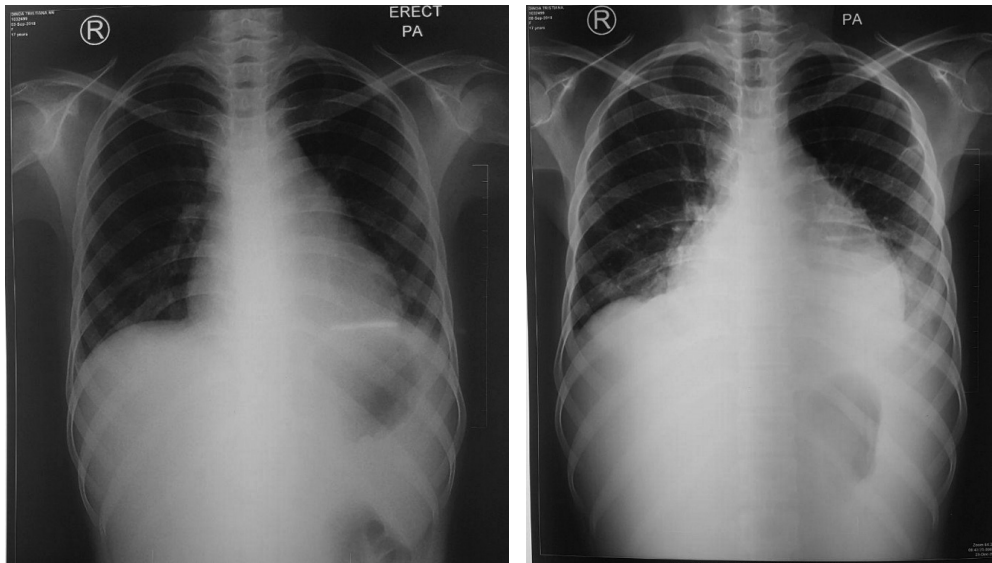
Case 3, Left: Chest X-ray on first day of admission at previous hospital. No abnormality was found except slight cardiomegaly with cardiothoracic ratio 0.56. Right: Chest X-ray on the sixth day of care. Cardiomegaly with water bottle shape and left pleural effusion.
